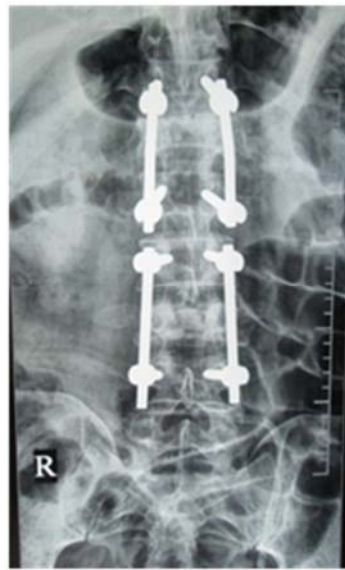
Radiographs of dorso-lumbar spine of a patient showing pathological vertebral body fractures due to metastases from small cell lung carcinoma. Fig – 8c, MRI picture showing spinal cord compression. Fig – 8d & 8e, Post operative radiographs of same patient after canal decompression and posterior stabilization.
